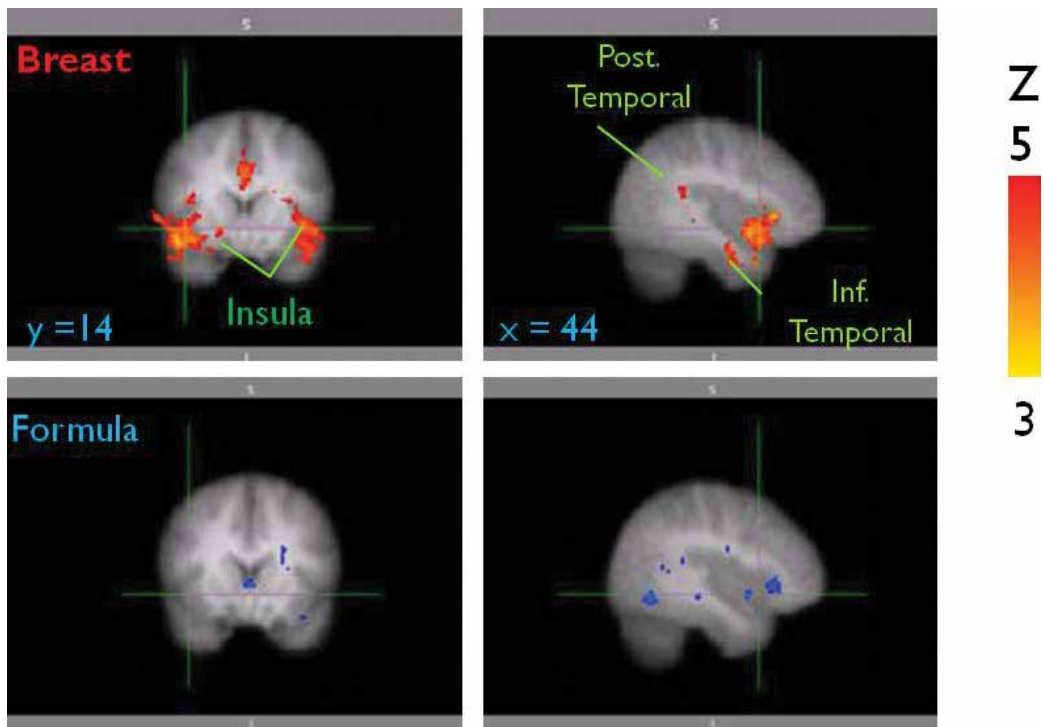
Comparison of the functional MRI studies of breastfeeding and formula feeding mothers after viewing the pictures of their own infants. Oxytocin receptors are significantly enhanced in breastfeeding mothers.
